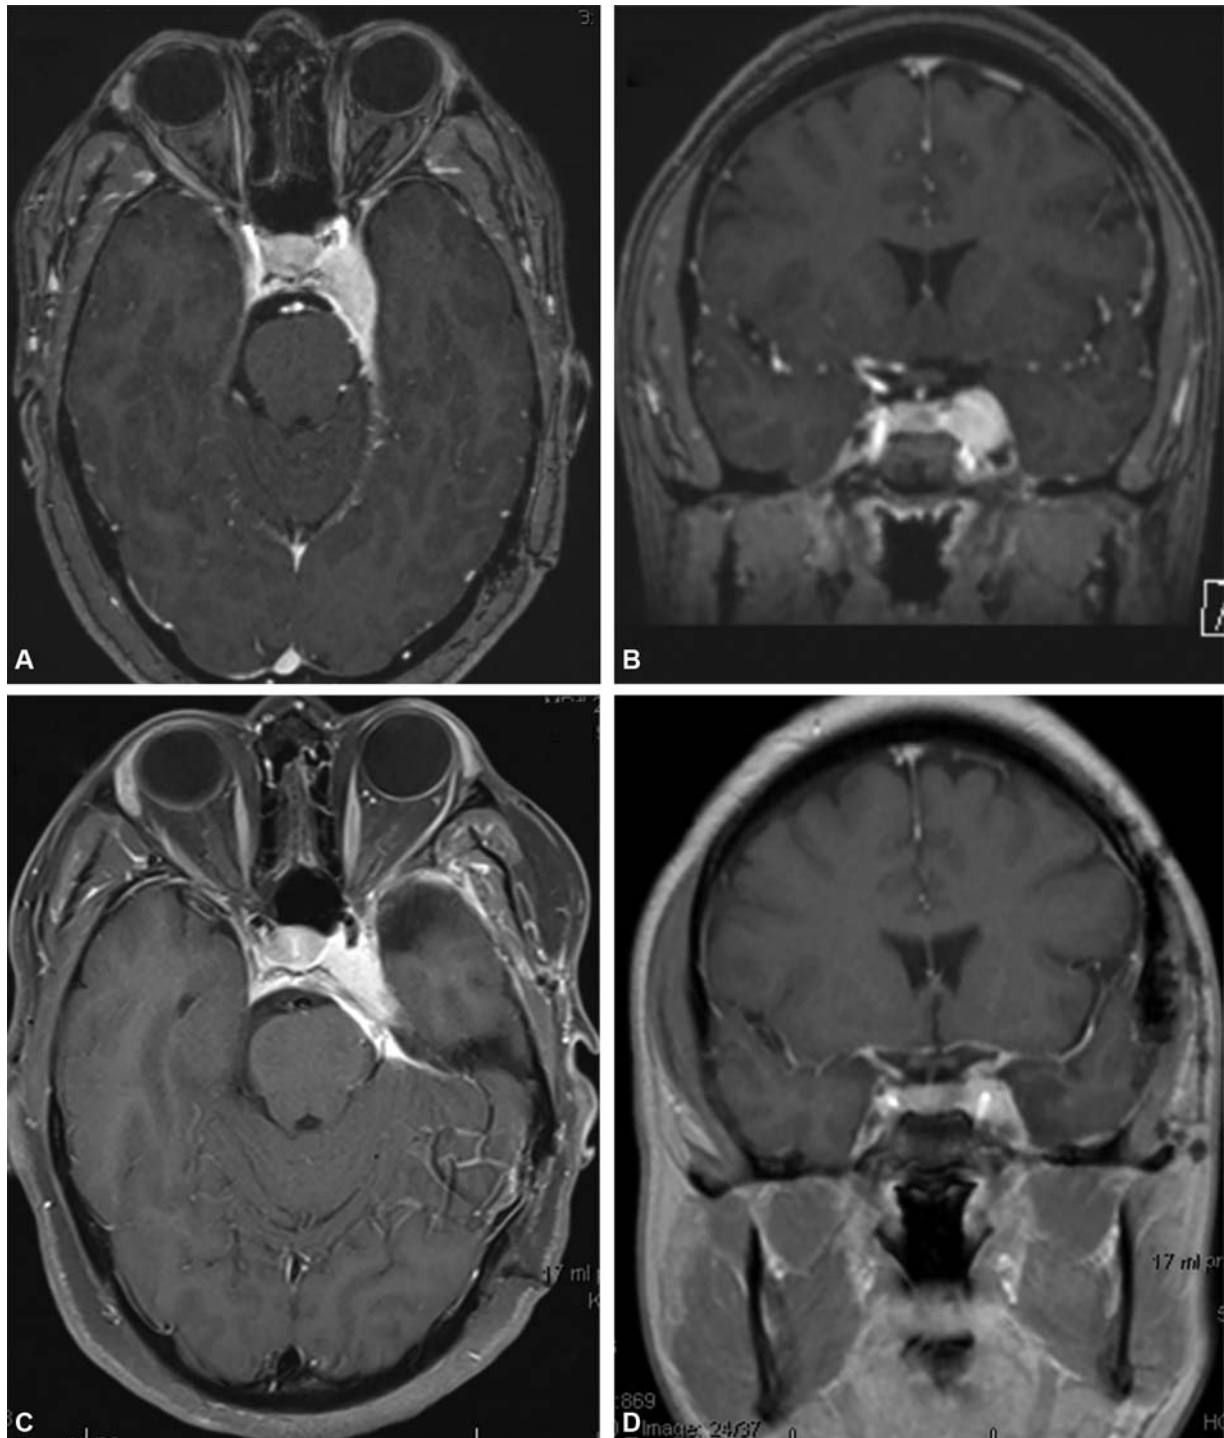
Postcontrast, T1-weighted magnetic resonance imaging showing a purely cavernous sinus meningioma. This 39-year-old woman presented with progressive left abducens palsy and evidence of an enlarging likely meningioma of the left cavernous sinus (A, B, preoperative axial and coronal images). She underwent a frontotemporal craniotomy and a left cavernous sinus decompression (C, D, postoperative axial and coronal images). She experienced improved lateral rectus function and was subsequently treated with stereotactic fractionated radiation therapy.
